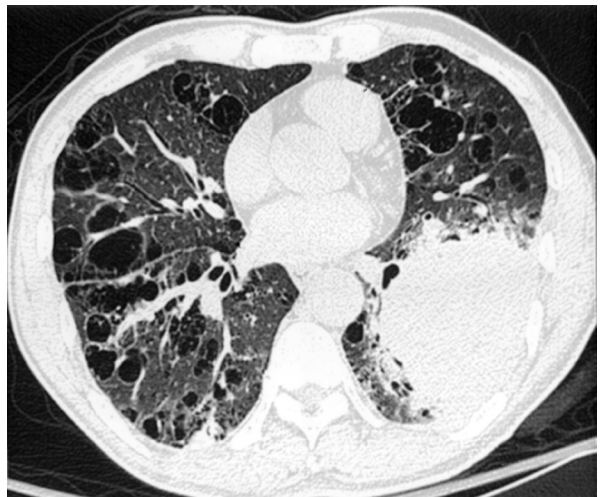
Diffuse cystic lesions found in both lungs in the HRCT scan, along with a huge mass in the left lower lobe
